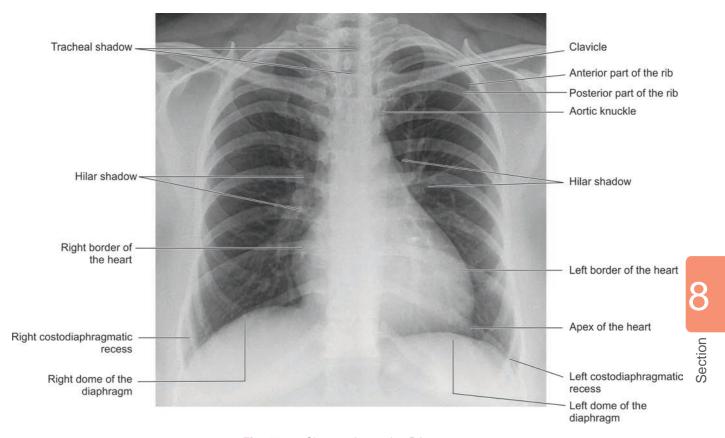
Chest radiograph—PA view
